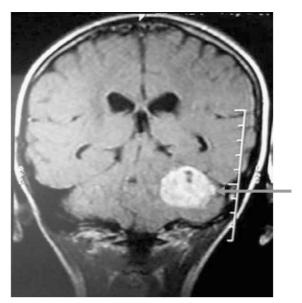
T2-weighted axial image shows a mass lesion in the left cerebellum (GBM).
